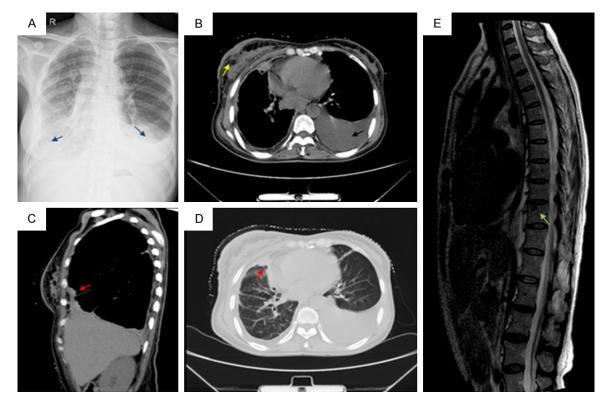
Imaging techniques. A. Chest x-ray: a little pleural effusion occupying the bilateral hemithorax (blue arrow); B. Chest computed tomography: The left lung is atelectatic and compressed by a little pleural effusion (black arrow). Additionally, right breast skin was thickened, a irregular mass with lobular boundary connected to thickening of the skin (yellow arrow); C. Chest computed tomography: Sagittal reformatted CT image demonstrates the presence of a neoplasm in the right parietal pleura (red arrow); D. Chest computed tomography: a nodular shadows in the front of the upper lobe that contact with the splanchnic pleura and approached the parietal pleura, in addition, adjacent pleural was thickened (red arrow); E. Magnetic resonance imaging: a metastasis to the 10th thoracic vertebrae (green arrow).
